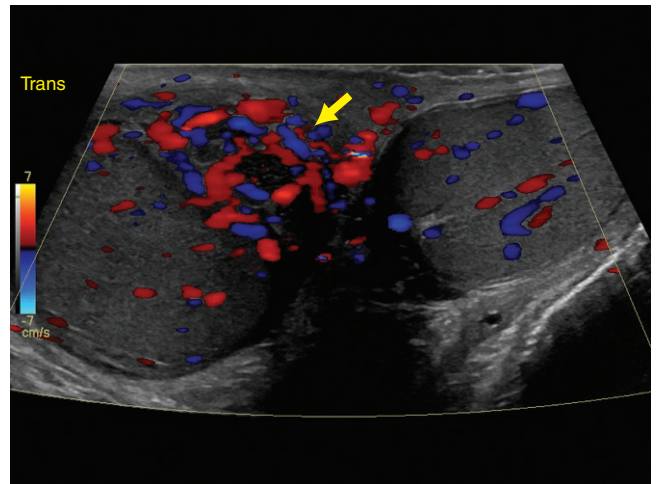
Color Doppler shows increased color in the enlarged right epididymis (arrow) and slight increased color in the right testis indicating mild orchitis.
